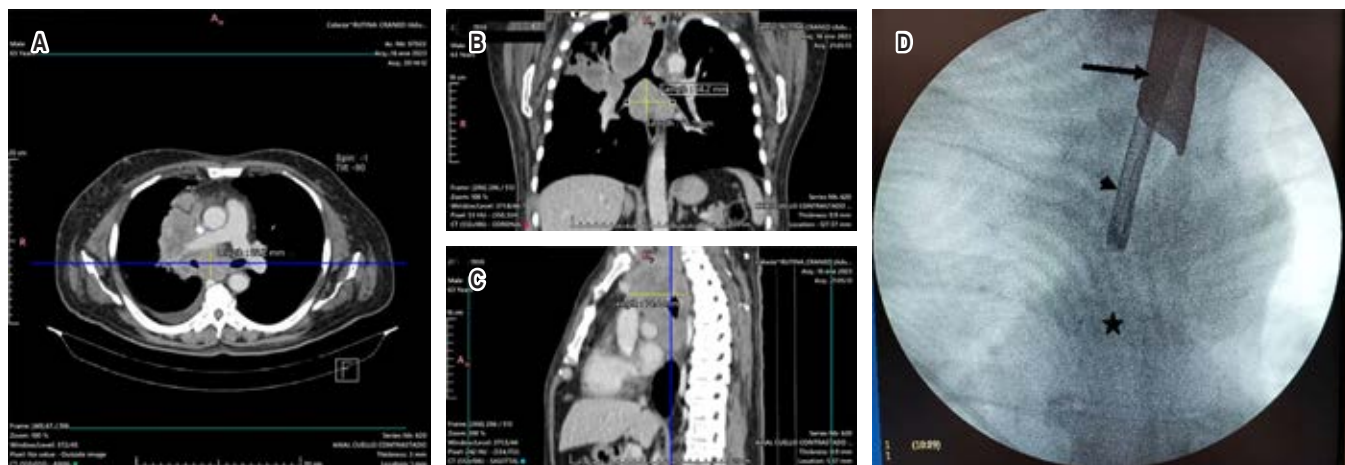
Contrast-enhanced chest CT scan mediastinal window with measurement of mediastinal node station VII in axial (A), coronal (B) and sagittal (C) views. D) Fluoroscopy image showing rigid bronchoscope (arrow), flexible bronchoscope (arrowhead), mediastinal node at node station VII (star).
